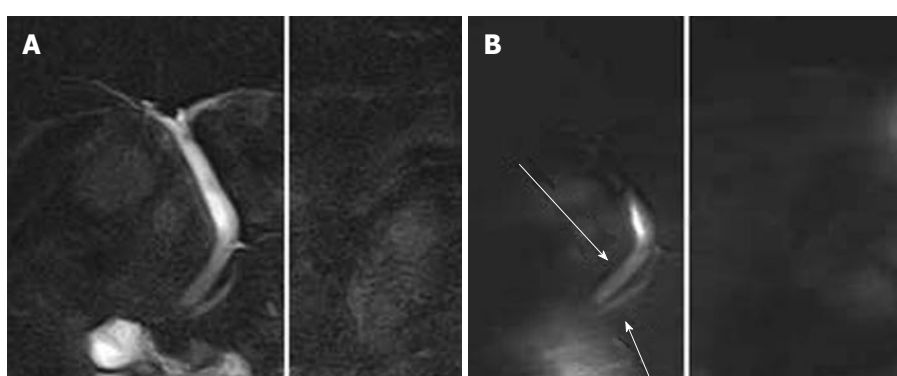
Pancreatic juice reflux into the biliary tree by time-spatial labeling inversion pulse imaging. A 56-year-old female patient underwent magnetic resonance imaging after abnormal laboratory findings. Magnetic resonance cholangiopancreatography revealed normal morphology, but time- spatial labeling inversion pulse imaging showed pancreatic juice reflux into the biliary tree. A: Magnetic resonance cholangiopancreatography image; B: Flow of pancreatic juice from body of the pancreas into the head of the pancreas is identified by high signal intensity (arrows).
